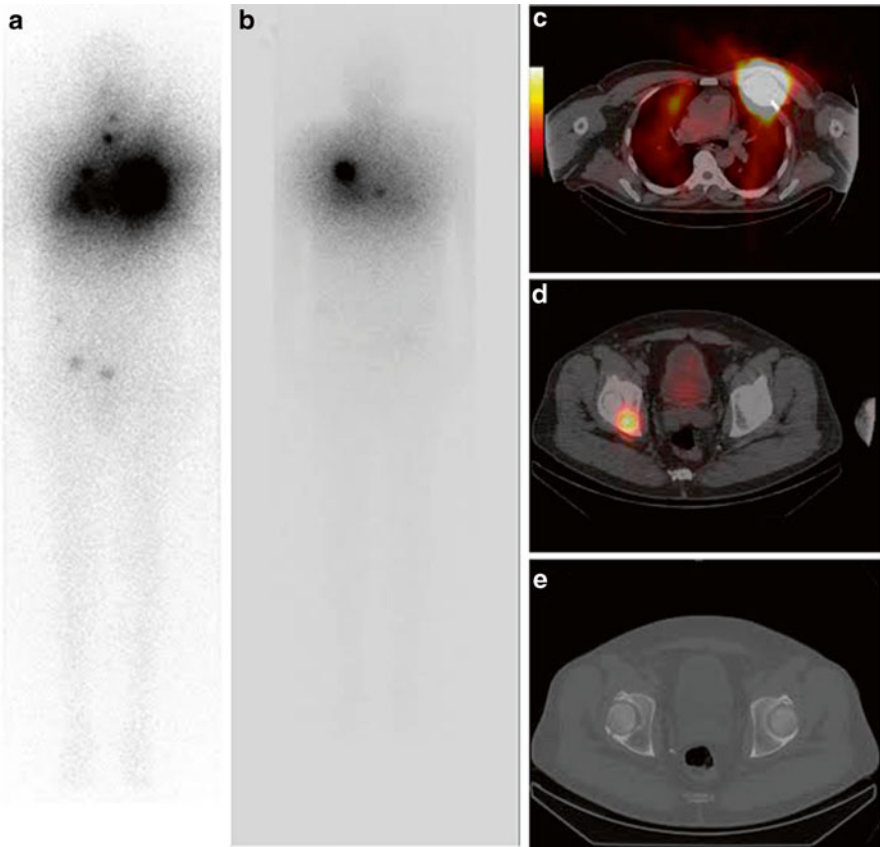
^{131}I post-therapy whole-body (WB) scan after administration of 100 mCi (3.7 GBq) after thyroid hormone withdrawal for 4 weeks. (a, b) Anterior and posterior view showing high ^{131}I uptake in the third left rib lesion, in the right ischial lesion, and in the spine T8 and a diffuse uptake in the lung. (c) Axial fusion image (SPECT/CT) showing high ^{131}I uptake in the third left rib. (d) Axial fusion image (SPECT/CT) showing high ^{131}I uptake in the right ischium. (e) Axial image of CT component of SPECT/CT showing a 23 mm lytic lesion in the right ischium
